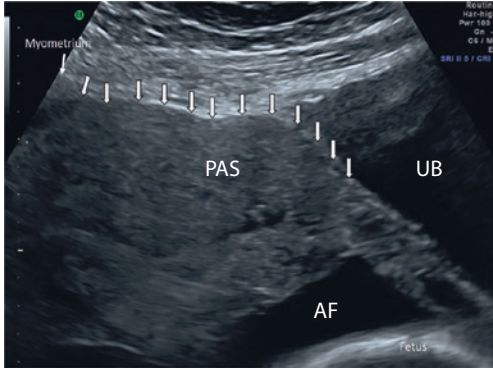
Thinning or absence of the myometrium. Sonographically, PAS shows reduced or absent hypoechoic myometrium above the placenta with $\leq 1\text{--}2$ mm or less. *UB* Urinary bladder; *AF* Amniotic fluid
